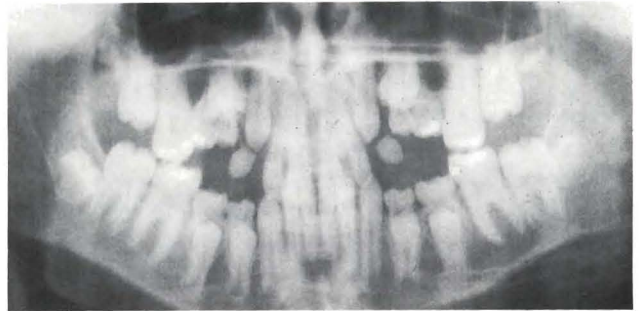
Orthopantomogram of a ten-year-old boy with secondary retention of all primary molars.
